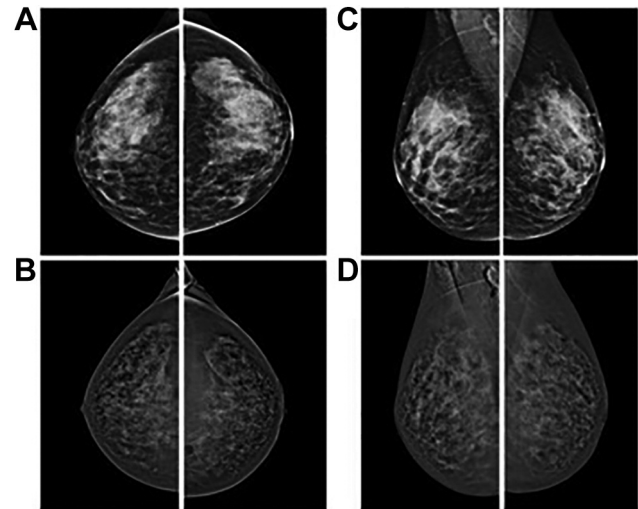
Case 3: 54-year-old II level CESM as II level imaging after DM and US; DM and CESM. A, C: CC and MLO digital mammography of high-density tissue (BI-RADS C-D). B, D: CC and MLO CESM projections with moderate BPE (grade 3). BI-RADS: Breast imaging-reporting and data system; BPE: background parenchymal enhancement; CC: craniocaudal projection; DM: digital mammography; MLO: mediolateral oblique projection; MLO: mediolateral oblique projection; US: ultrasound; CESM: contrast enhanced spectral mammography.
